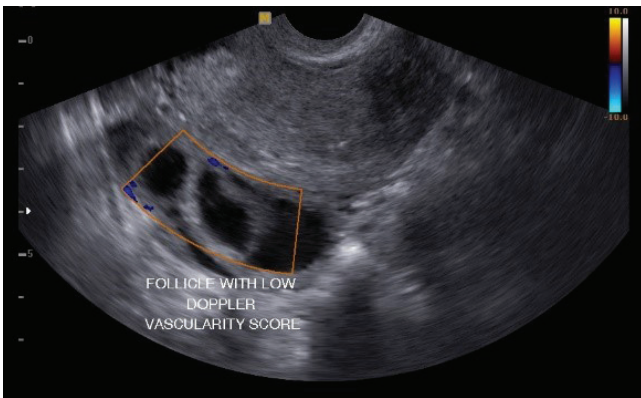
Follicles with low Doppler vascularity score
